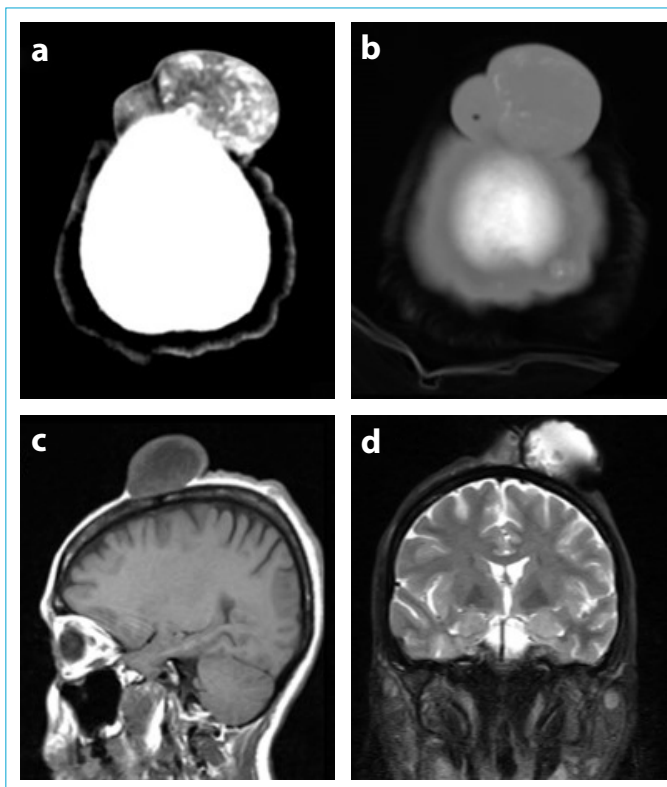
(a) Computed tomography showed a heterogenous lesion with calcifications, (b) and minimal thickness of the bone. (c) Sagittal and (d) coronal MRI revealed no parenchymal invasion.
